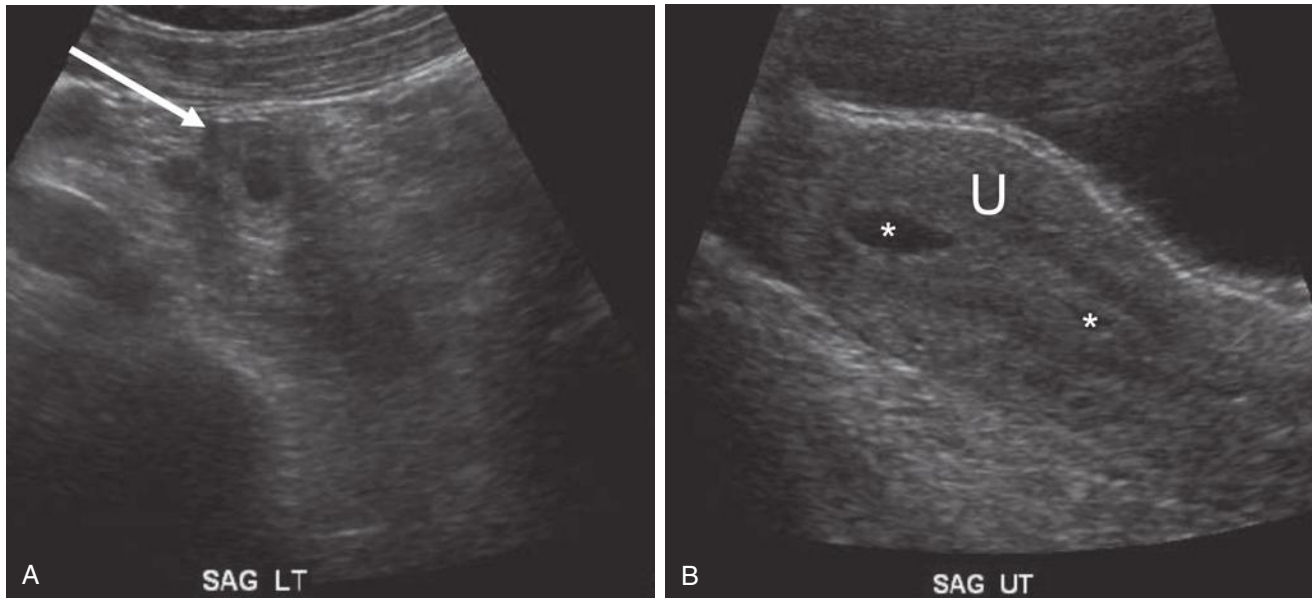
Value of a transabdominal scan in finding an ectopic pregnancy. A, Transabdominal longitudinal scan of the pelvis showing the echogenic tubal ring of a small ectopic pregnancy (*arrow*) situated above the uterine fundus (not shown). B, Transabdominal midline longitudinal scan of the uterus (U) shows a small amount of anechoic fluid in the endometrial cavity (*asterisks*), indicating a small amount of intrauterine blood. Transvaginal sonography could not image the ectopic sac because of its high location.
